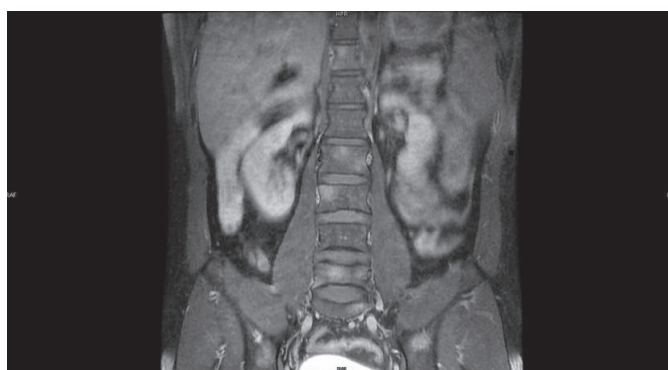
Magnetic resonance imaging scan of spine showing diffuse multifocal tuberculosis of T7 to T12.
